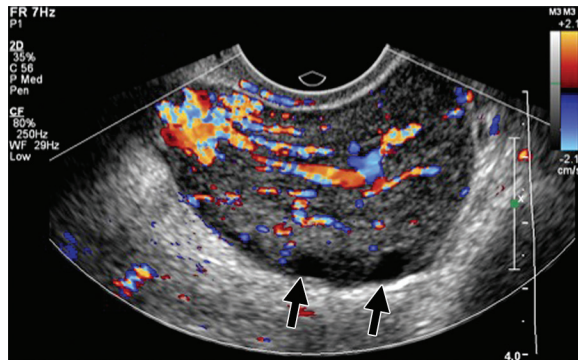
Early PID: oophoritis in a 24-year-old woman presenting with right lower quadrant pain. Sagittal transvaginal color Doppler US image of the right adnexa shows an enlarged, edematous, and hyperemic right ovary. Note the peripheral displacement of multiple small follicles (arrows), which gives the ovary a polycystic-like appearance.
